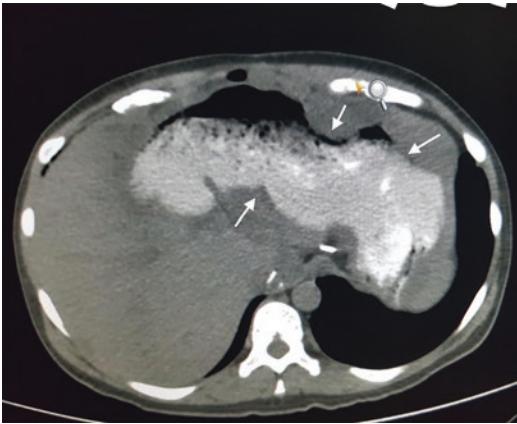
CT scan showing extensive infiltrative deposits encasing the body of the stomach that will require a total gastrectomy for complete cytoreduction in that region
